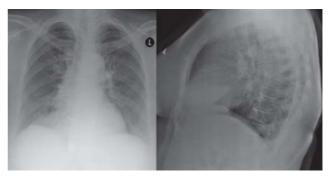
Chest radiograph (PA and lateral views) showing smaller right-sided para-mediastinal opacity.
